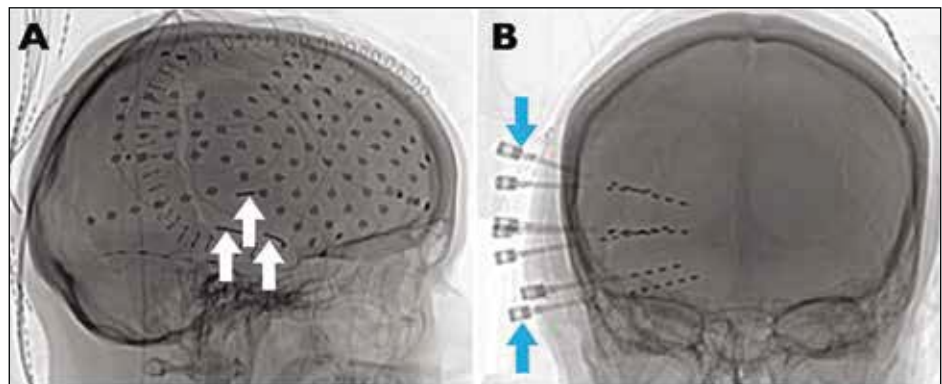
Intracranial monitoring for MRI-negative epilepsy. Depth electrodes may be placed during a craniotomy for grid and strip electrode placement (A, white arrows) or via skull-mounted anchor bolts (B, blue arrows) for SEEG.
